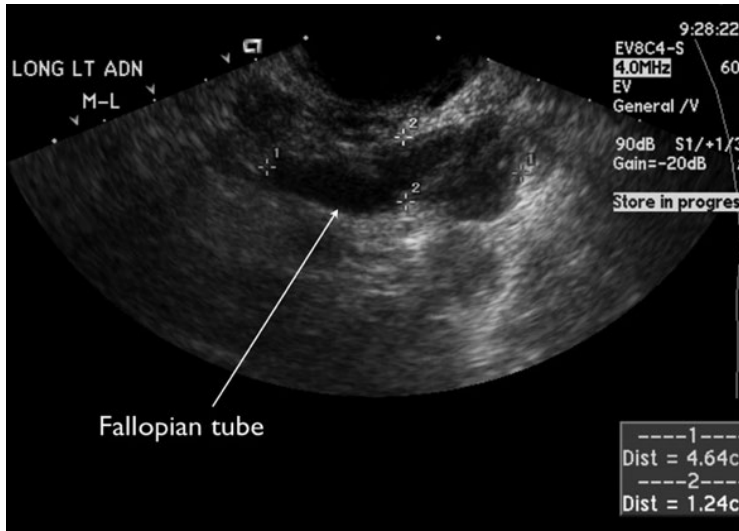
Hydrosalpinx. Longitudinal transvaginal sonogram showing the characteristic folded tubular configuration of a distended fallopian tube filled with fluid, and a well-defined echogenic thickened wall.
